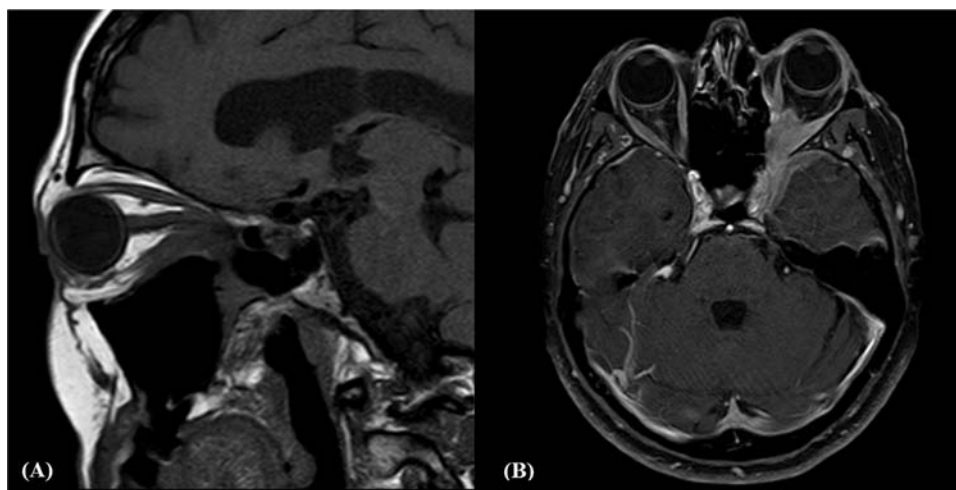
Magnetic resonance imaging of brain and orbits. Irregular infiltrative lesion in the left orbital apex with extension into the left cavernous sinus and left anterior temporal lobe extra-axial space seen on (A) sagittal cut on T1 and (B) axial cut on T1 with gadolinium.
